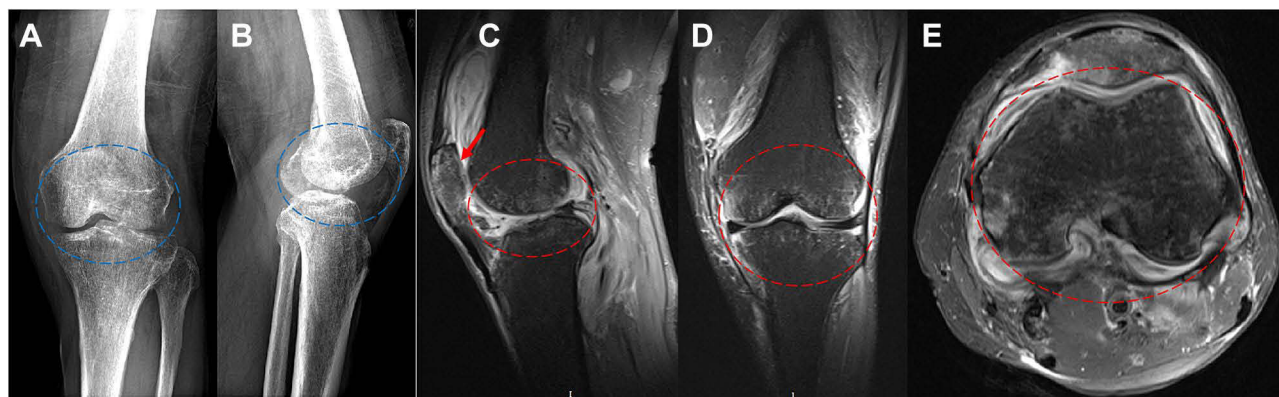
On admission to the hospital, X-ray and MRI images were taken of the left knee joint. (A and B) An X-ray of the distal femur and the proximal tibia revealed patches of osteopenia (blue circle). (C–E) There was a synovial infection in the knee joint, a localized full-thickness defect in the patellar cartilage (red arrow), and a diffuse patchy signal in the bone marrow on T2-weighted imaging (red circle).
